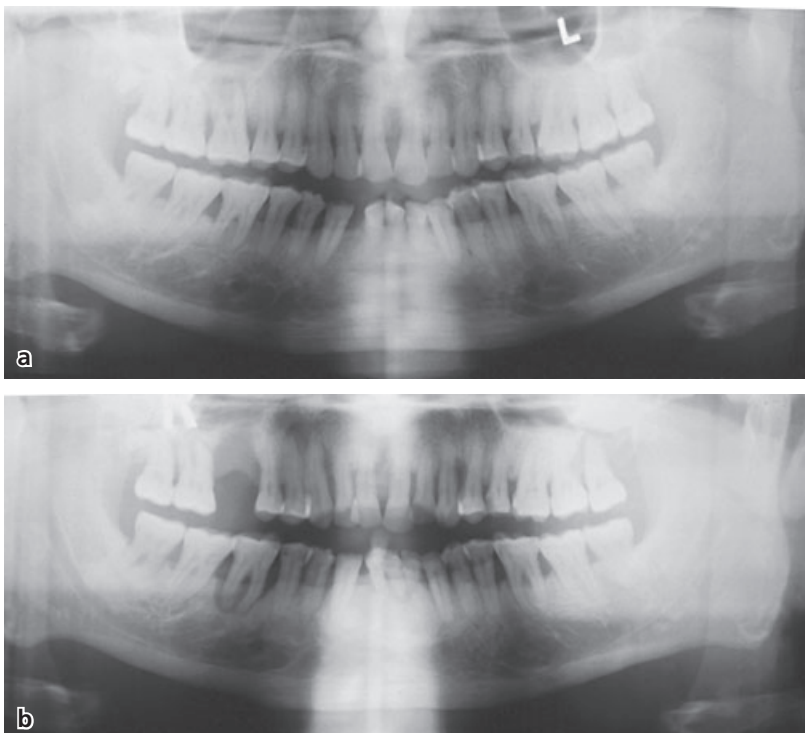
Radiographs of a 50-year-old male who developed type 2 diabetes mellitus in the period between the two radiographs which were taken 3 years apart. There has been rapid bone loss and tooth loss associated with recurrent multiple periodontal abscesses.
